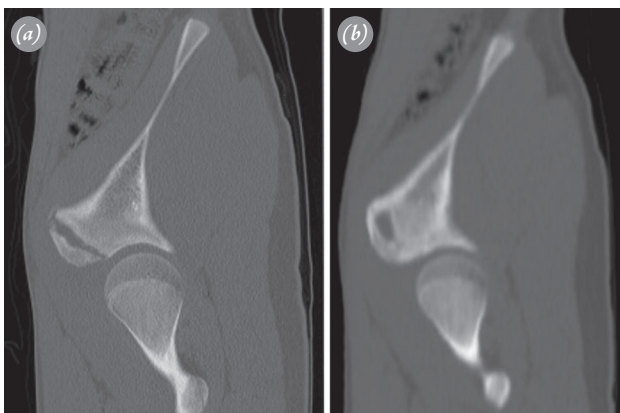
(a) Sagittal computed tomography scan showing the fracture and simple bone cyst and (b) signs of normal bone healing after 8 weeks.
